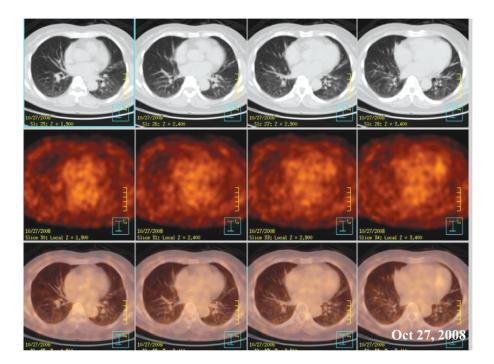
The F18-FDG-PET/CT show non-FDG avid lesion in right middle lobe, which could be a benign lesion. Pulmonary tumorlets and bronchioalveolar carcinoma may also be non-FDG avid lesion.
